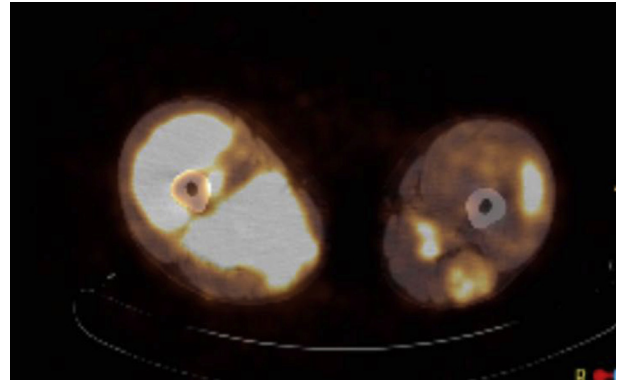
PET-CT scan of legs.
